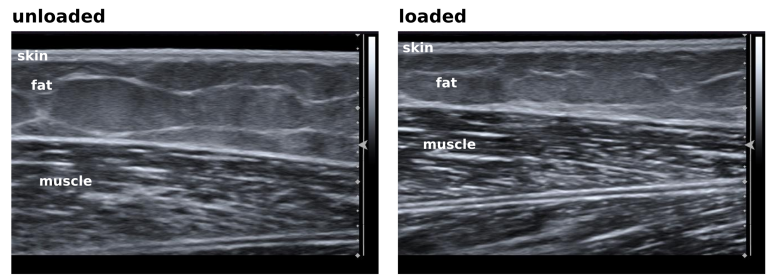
The team can utilize ultrasound to measure unloaded thicknesses of tissue layers and their deformations during indentation of the multi-layer tissue surface using the ultrasound probe. Posterior region of the upper arm is shown with an imaging depth of 30 mm.
